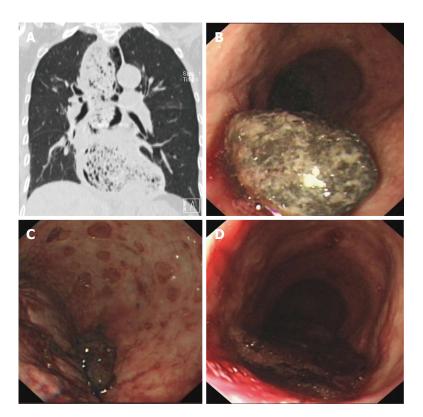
CT and endoscopy imaging. A: CT showed lower esophageal dilatation and esophageal wall thickening; Upper endoscopy revealed; B: A large, dark round stone; C: Multiple ulcers on the esophageal wall; D: A slit in the cardiac mucosa with a large clot attached.
